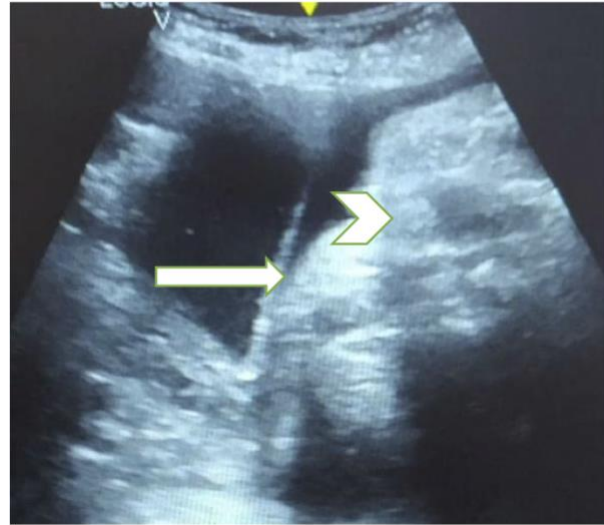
A coned down grey scale ultrasound image showing a linear echogenic structure (arrow) extending into the amniotic cavity from the placenta (arrowhead) consistent with an amniotic band.
